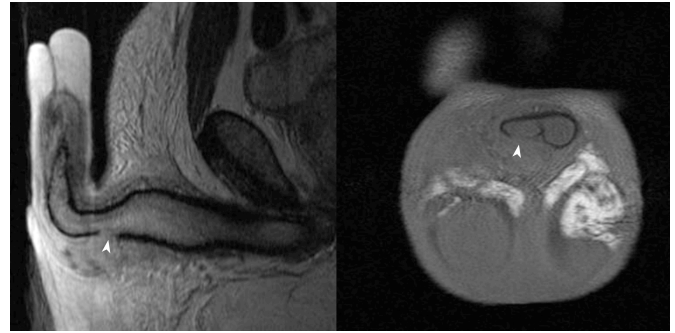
Defect in Tunica Albuginea (white arrow) on T2-weighted Sagittal and T1-weighted Coronal MRI.
